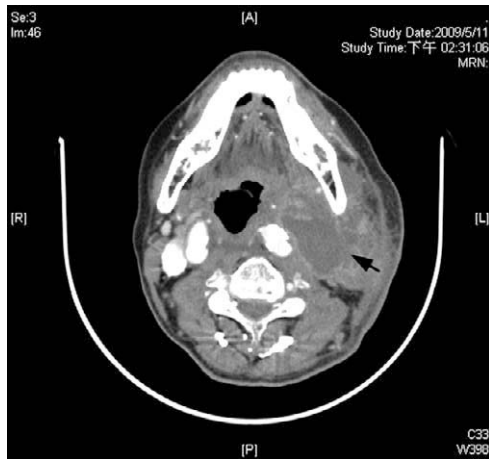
Computed tomography showed a cystic necrotic lesion with rim enhancement in the left parapharyngeal space.
